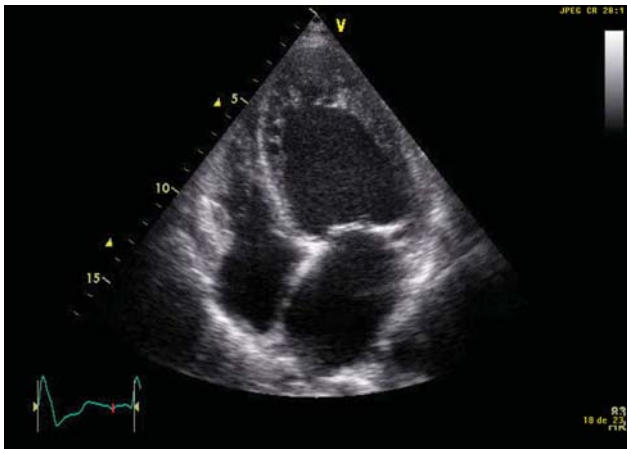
Apical four-chamber view. Prominent trabeculations at the apex of the left ventricle are clearly visible. The location in apical segment is typical for IVNC. A ratio of non-compacted/compacted myocardium ≥ 2 is diagnostic for IVNC.
